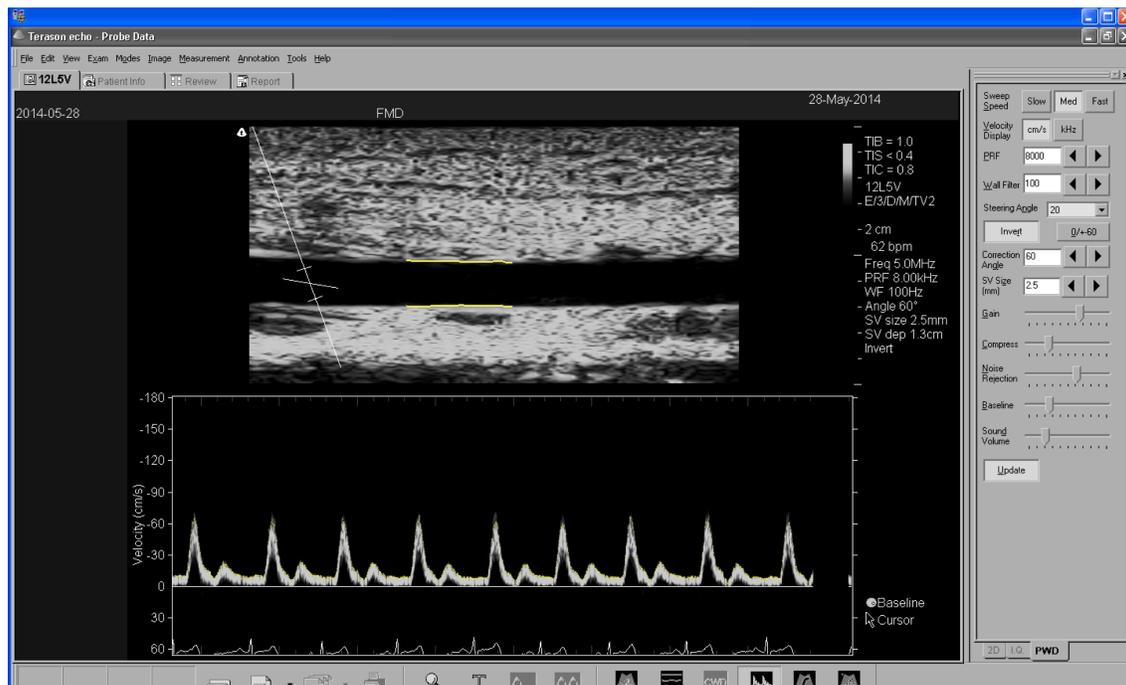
Ultrasound 2D image of the brachial artery (top panel) and Doppler blood velocity (bottom panel) from one representative subject approximately 1 min following release of a 5-min arterial occlusion. Wall tracking software was used to quantify changes in vessel diameter (yellow lines) and peak blood velocity (yellow dots).
